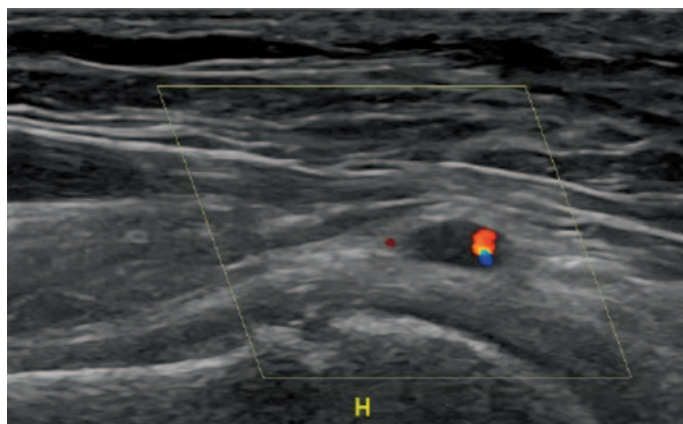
Color Doppler image of the axillary artery of a woman aged 66 years, with temporal arteritis and no palpable radial pulse in the right arm
